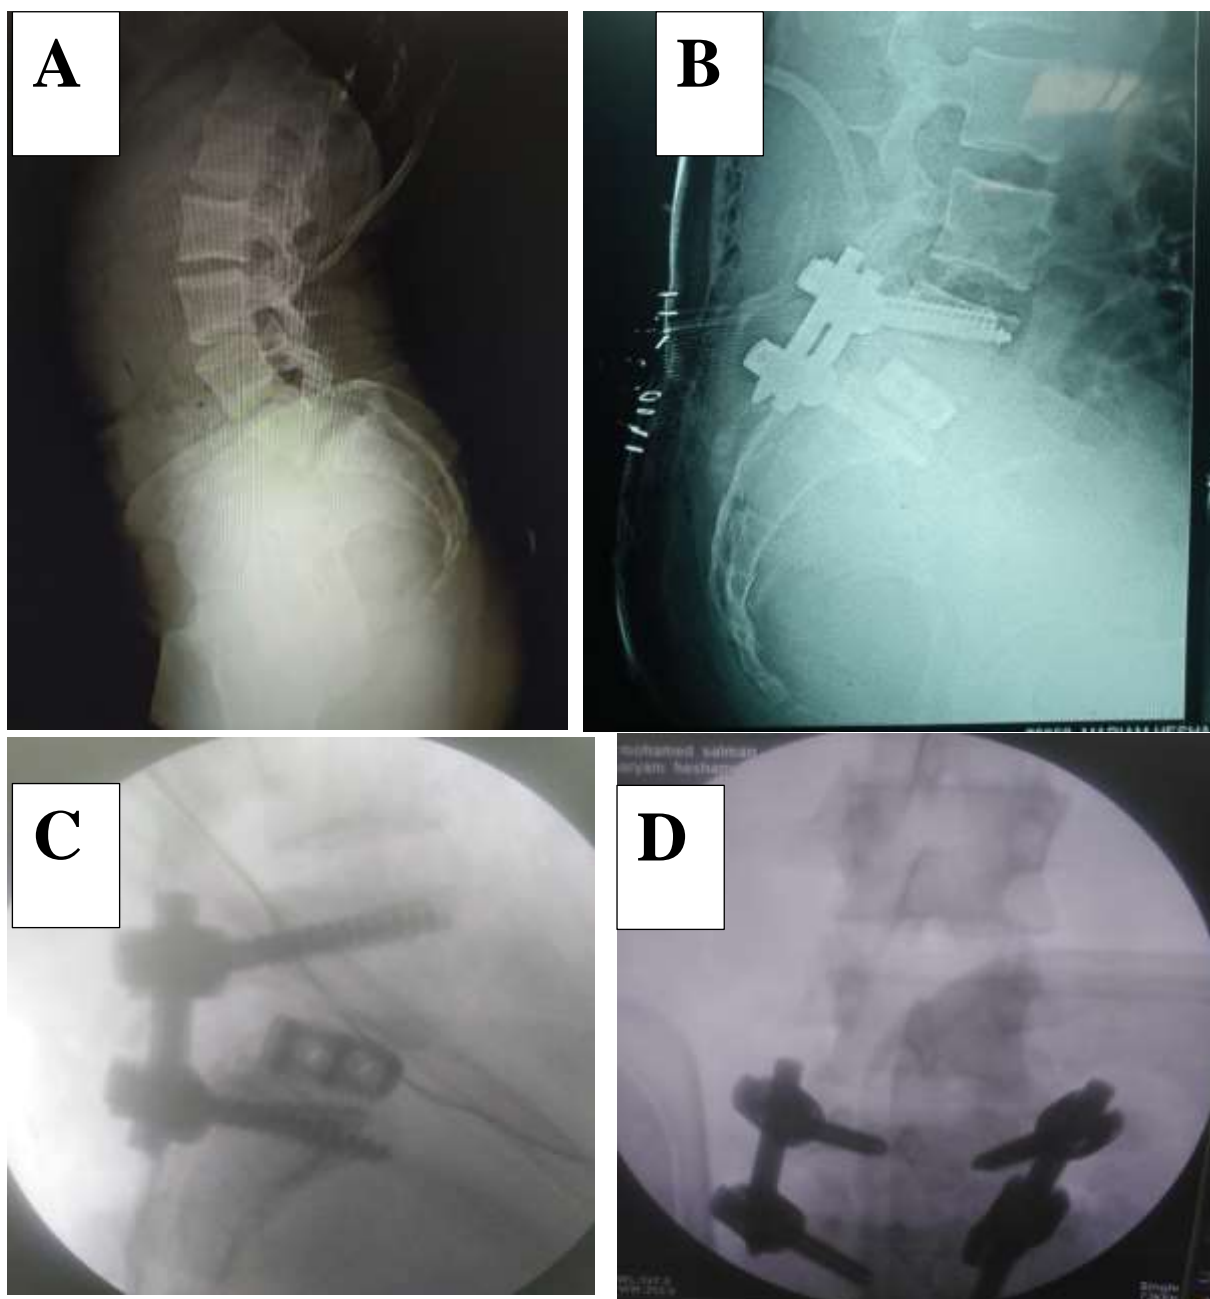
A: Pre-operative lateral view x-ray showing the spondylolisthesis. B, C and D: post-operative x-rays
